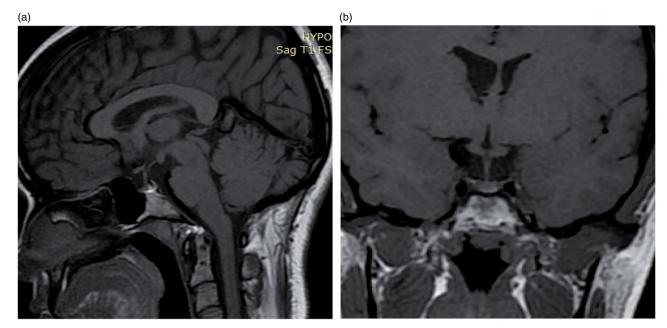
Pituitary sagittal (a) and coronal (b) magnetic resonance imaging scans showing hypoplastic adenohypophysis for patient case 6 (V3).
